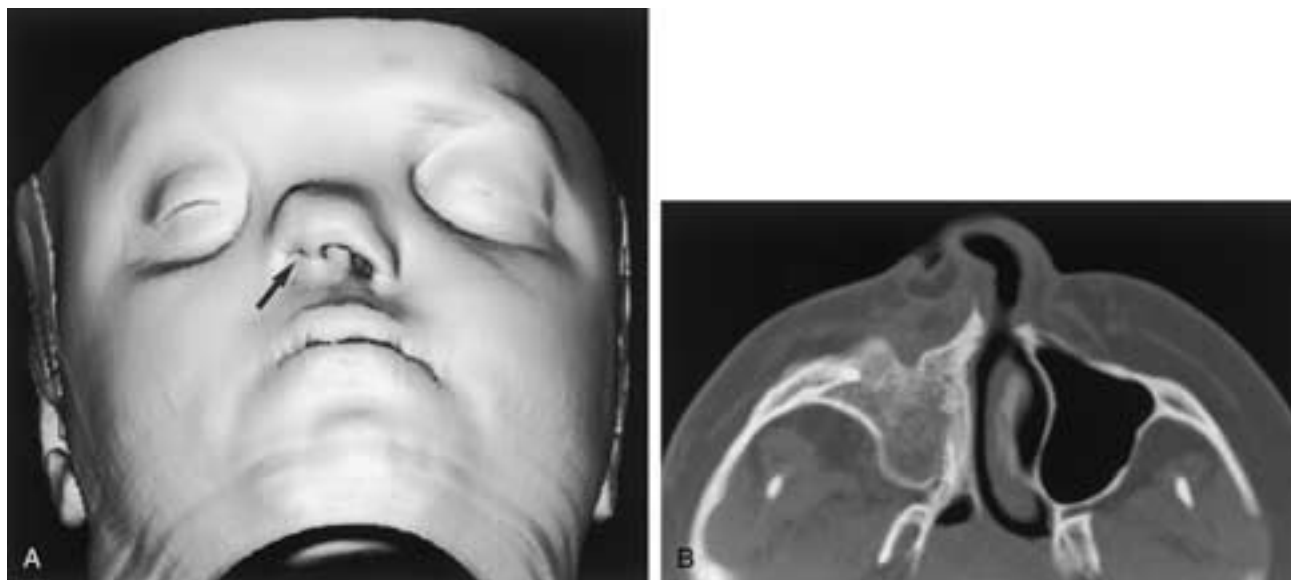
Frontoorbital and nasomaxillary dysplasia in a 16-year-old girl. A, Three-dimensional CT of the face reveals facial asymmetry and right nasal hypoplasia with a small depression at the location of the right nostril (arrow). There is hypertelorism and right microphthalmos. B, Axial CT shows absence of the right nasal cavity and right maxillary antrum.
